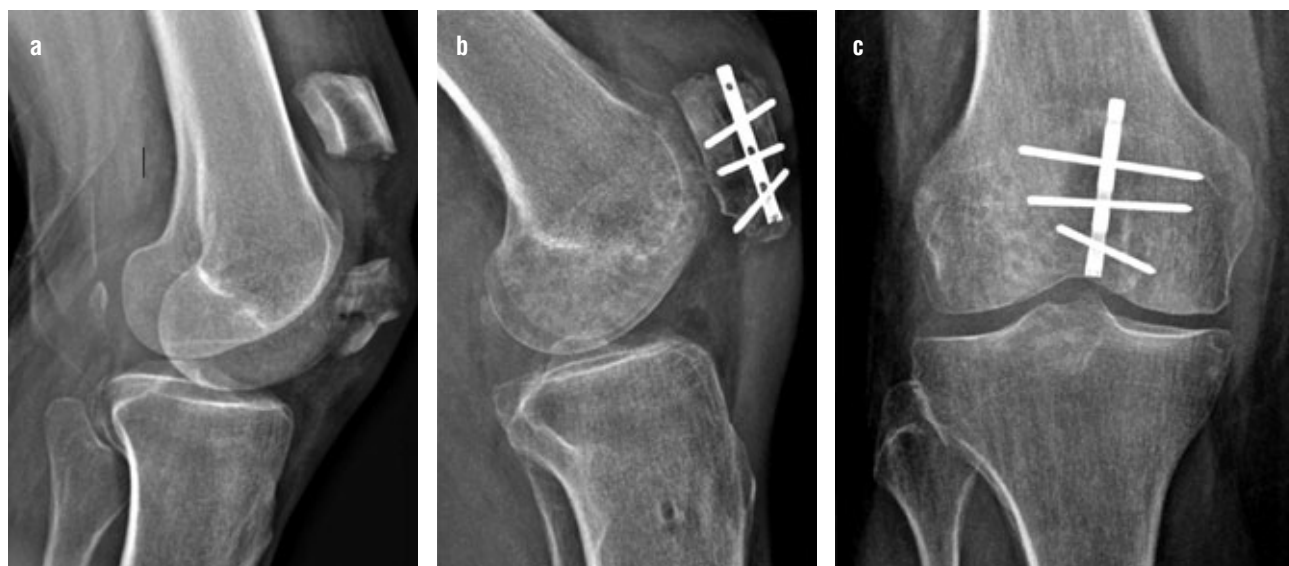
Pre- (A) and postoperative X-ray (B, C) after XSN treatment of a patella fracture (source: own).
